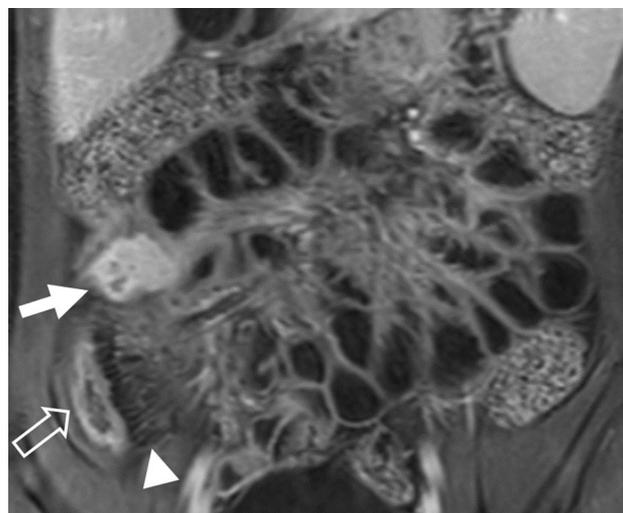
Coronal T1-weighted fat-saturated post-contrast MR enterography image demonstrates penetrating disease (solid arrow) associated with the terminal ileum (open arrow), which has a heterogenous appearance. Note the engorged vasa recta (arrowhead) at the mesenteric border of the inflamed terminal ileum. 5 of 5 readers were in agreement for the presence of penetrating disease in this patient. However, agreement was lacking for the type of penetrating disease, with 1 reader choosing “complex fistula”, 2 readers choosing “inflammatory mass”, and 2 readers choosing “abscess.”.
